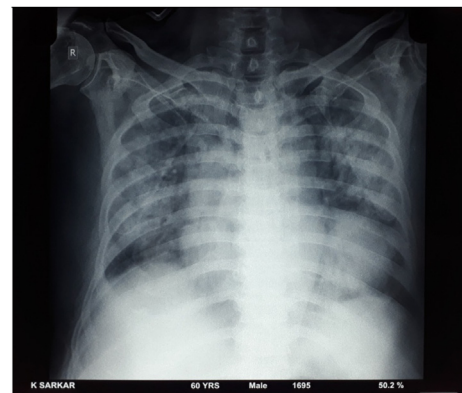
Chest xray after 3days of steroid administration (Day 7 of hospitalisation) showing less dense opacities compared to previous film.
